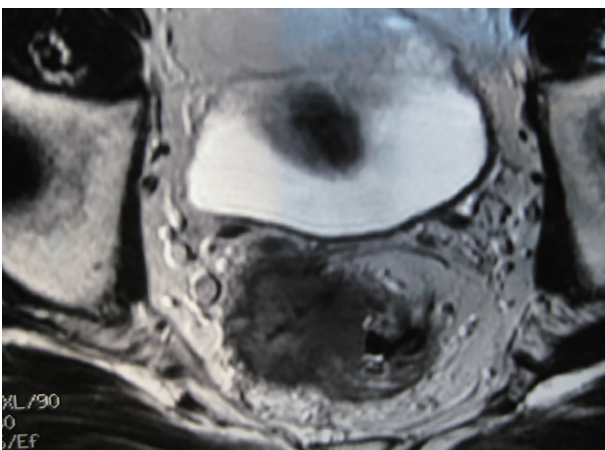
Magnetic resonance imaging before chemoradiotherapy.
